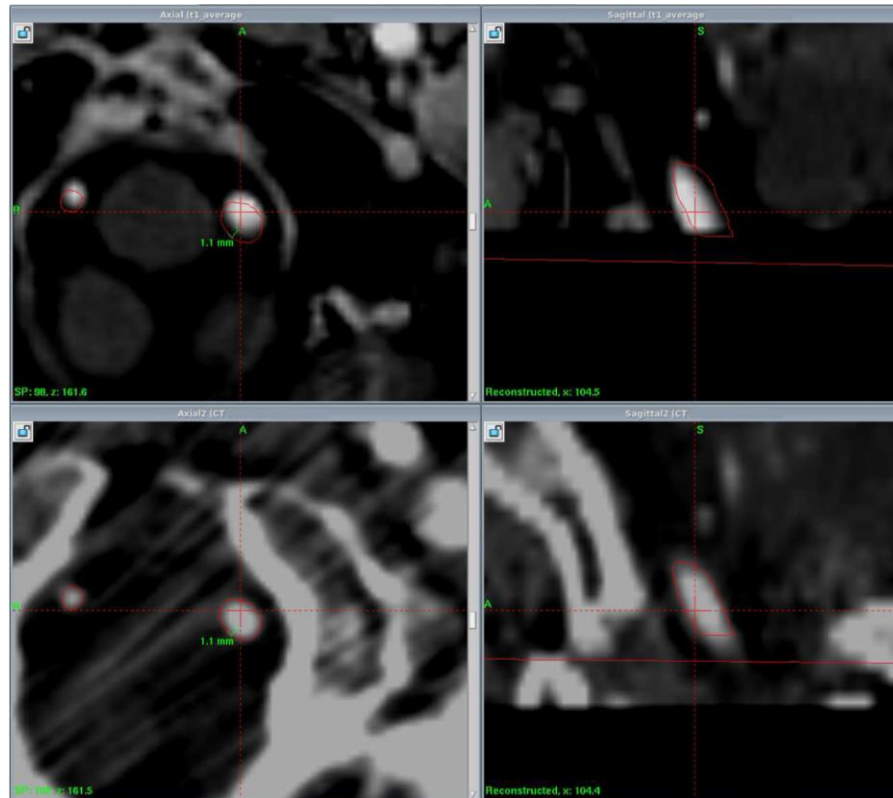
Snapshot of Leksell GammaPlan v.10 treatment planning system. Post-Gd axial image (left) and sagittal reformat (right) of the derived "average" MRI dataset (top row), along with corresponding CT-angiography images (bottom row) in the brain stem area of the scanned patient. The vertebral arteries lying in the vicinity of the frame base, but still within the treatable area with Perfexion, were contoured (red polygons) at the level of the foramen magnum on the CT series and superimposed to the MRI series.
